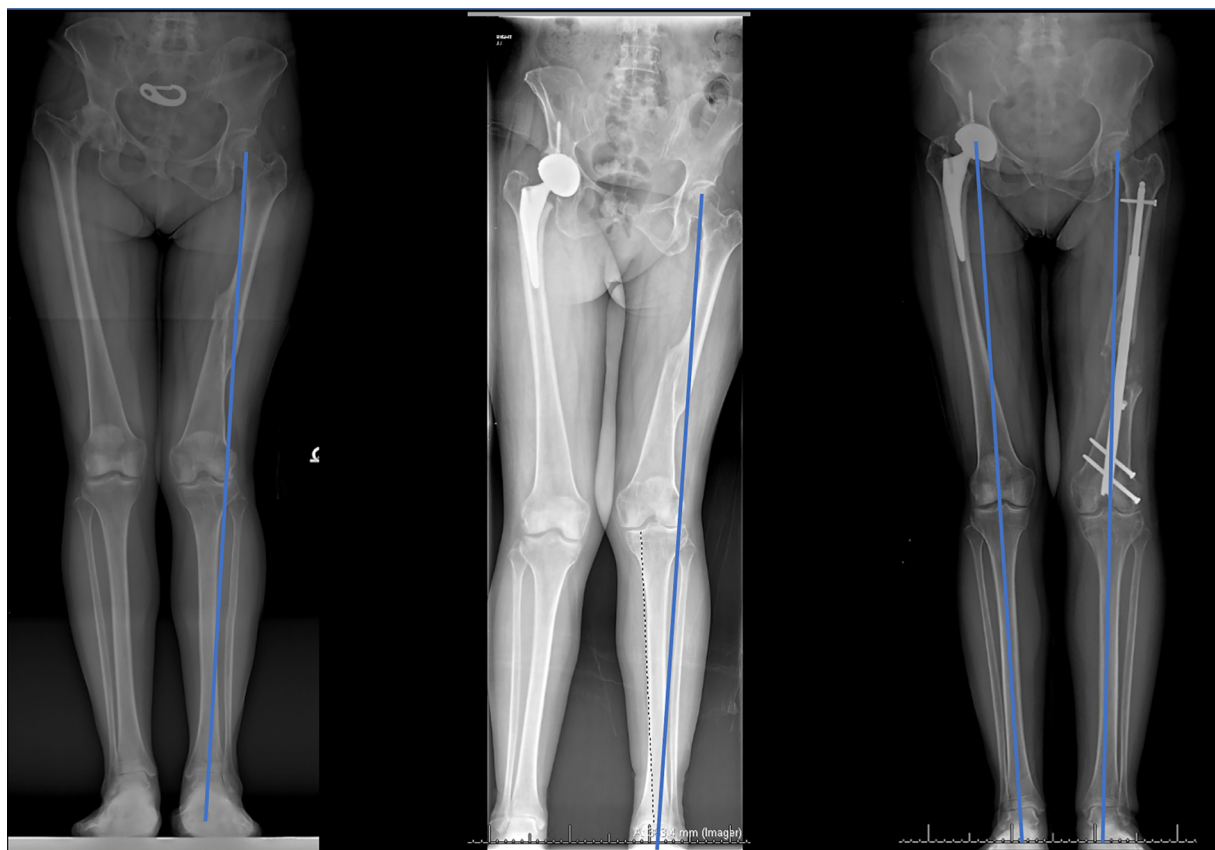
(A-C) AP radiographs at first presentation, post-THA, and 4 days prior to completion of lengthening with alignment corrected.
